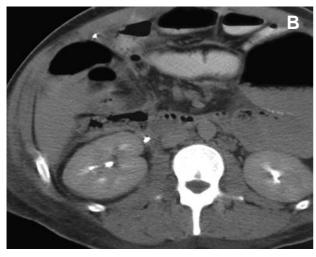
A) Stab wound to right flank with medial perirenal contrast material extravasation on preoperative trauma computed tomography (CT). A 4 cm laceration to the right renal pelvis was successfully repaired using 5-0 PDS suture with the application of a bolster of 5 cc of fibrin sealant over the suture line to reinforce urinary tract seal. No drain was placed. B) Postoperative CT image obtained 72 hours later demonstrates drain-free intact repair over ureteral stent without evidence of extravasation or urinoma.
